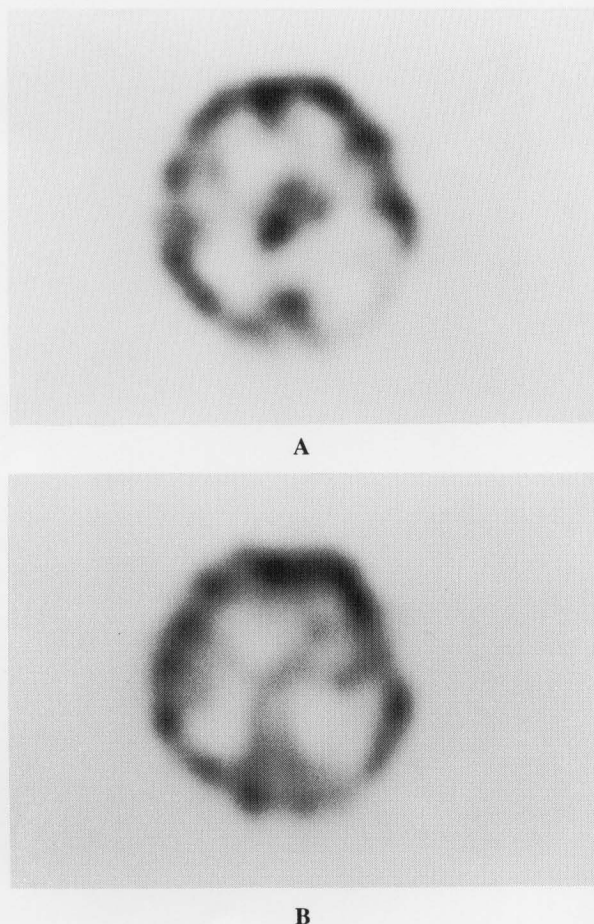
N-isopropyl-p-I-123 iodoamphetamine SPECT images (axial). The early image (A) showed a significant IMP uptake for the residual tumor but delayed image (B) showed a decreased uptake for the tumor.
